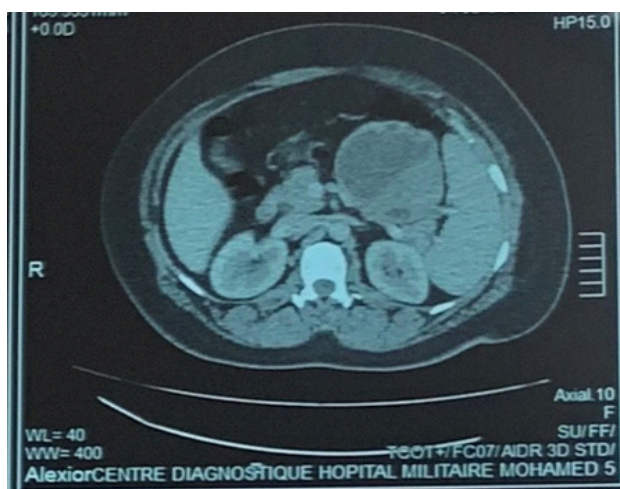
Abdominal CT scan showing a pancreatic tail mass with tissular and cystic components.
